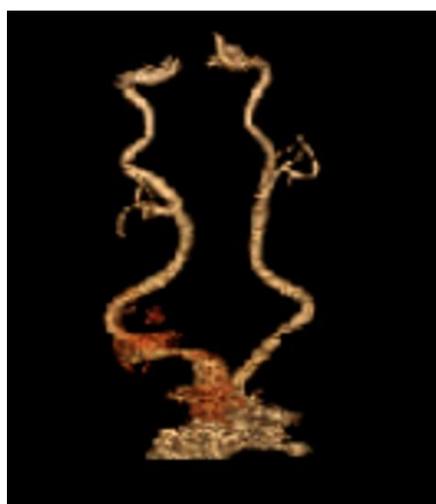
CT angiography (CTA) uncovering the following findings. a) No large vessel occlusion. b) 50% stenosis at the origin of the left cervical internal carotid artery. c) Severe, 70% plus stenosis at the origin of the left subclavian artery. D) Intracranial atherosclerotic disease including moderate bilateral supraclinoid ICA stenosis, severe stenosis in a proximal left M2 branch, severe stenosis in the left A1 segment anterior cerebral artery, multifocal moderate stenosis in the bilateral anterior cerebral arteries, and severe focal stenosis in the left P1 segment posterior cerebral artery.
